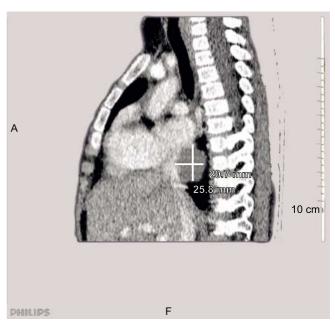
Enterogenic cyst in the chest CT
